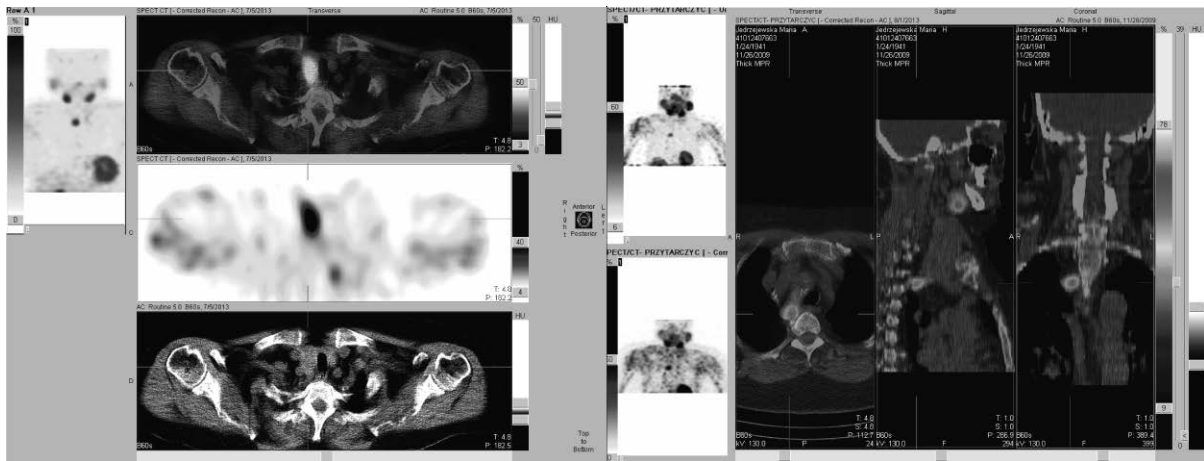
SPECT/CT of parathyroid glands.
